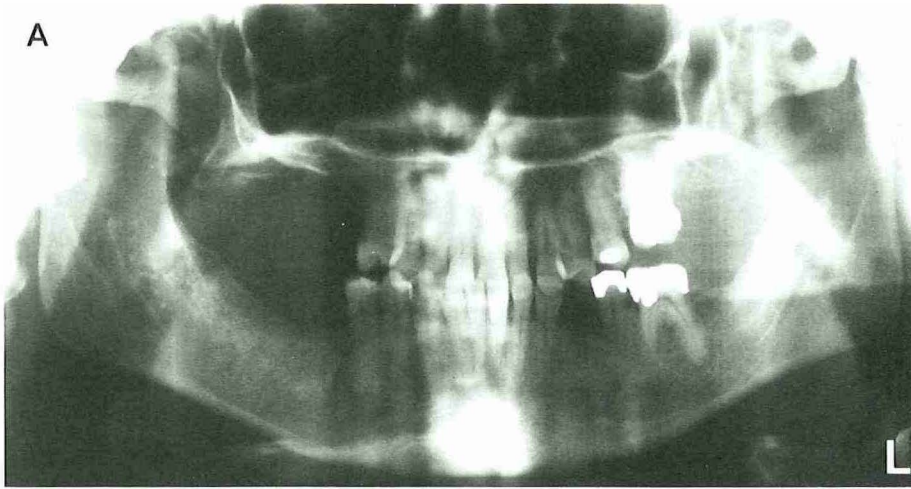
A Orthopantomogram of the mother showing secondary retention of the maxillary left first molar. B Orthopantomogram of her 10-year-old son showing secondary retention of the maxillary second deciduous molars.
